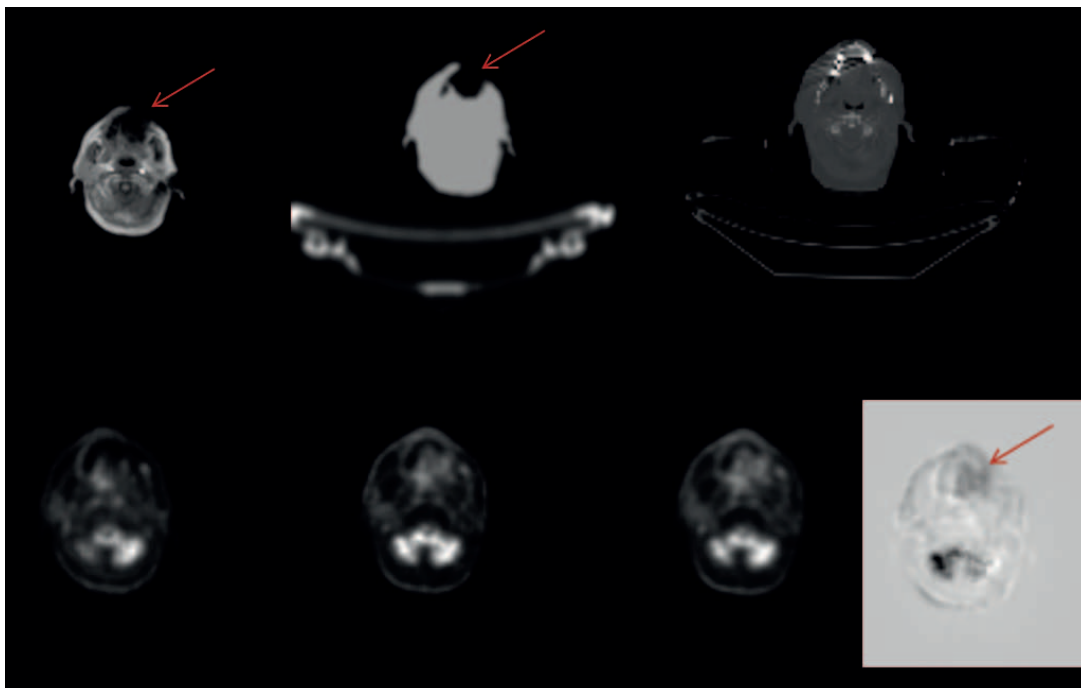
Upper row from left; MRI image, MRI AC binary map and corresponding CT image. Lower row from left; PET image obtained with MRI AC and matched PET images from PET/CT obtained with MRI-CT matching and PET-PET matching. Last image shows the difference between the first and the second PET image. The arrows indicate the area affected by dental filling artifacts. Differences shown in right inferior cerebellum area are due to small missregistration between the PET images.
